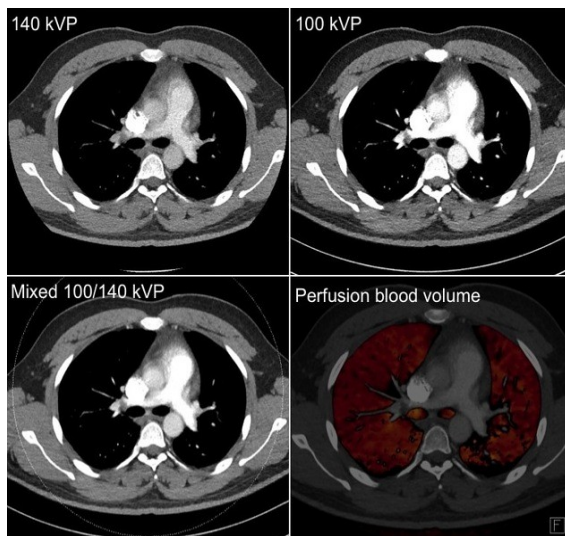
dual energy CT chest [17].
